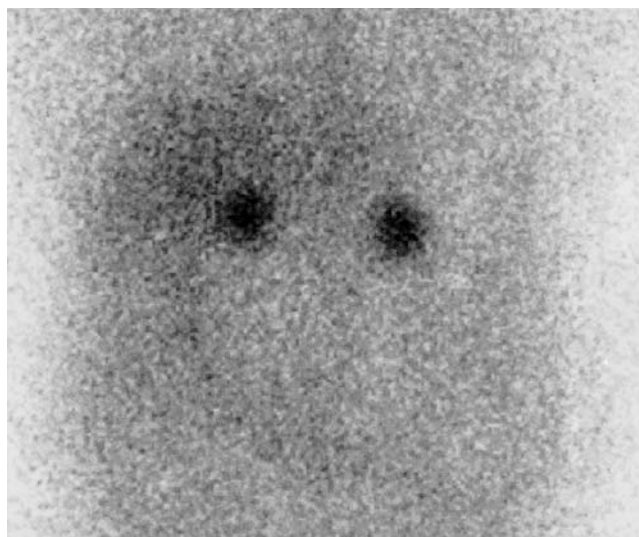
Adrenal scintigraphy revealed tracer accumulation in both adrenal glands
